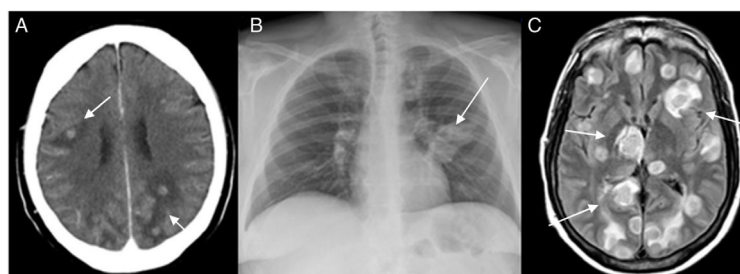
A) Brain CT scan showing juxtacortical lesions (arrows), in both cerebral hemispheres, with perilesional oedema. B) Chest X-ray showing left perihilar opacity (arrow) with probable associated lymphadenopathy. C) Brain MRI scan, FLAIR sequence, showing numerous ring-shaped hyperintense intraparenchymal lesions (arrows) in both cerebral hemispheres, with a hypointense peripheral ring and surrounding oedema.
